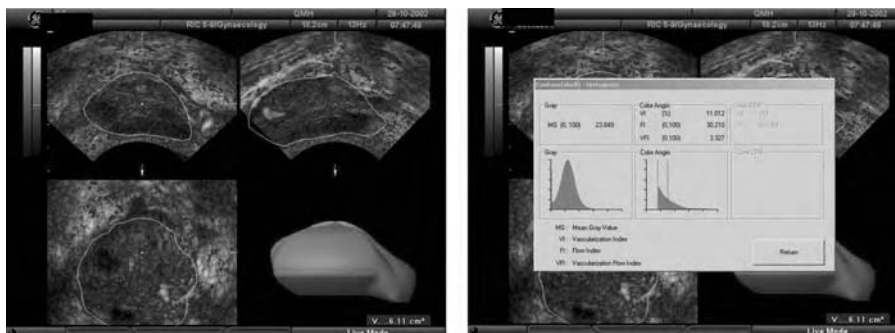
Ovarian stromal blood flow of polycystic ovary measured by three-dimensional ultrasound with power Doppler.
